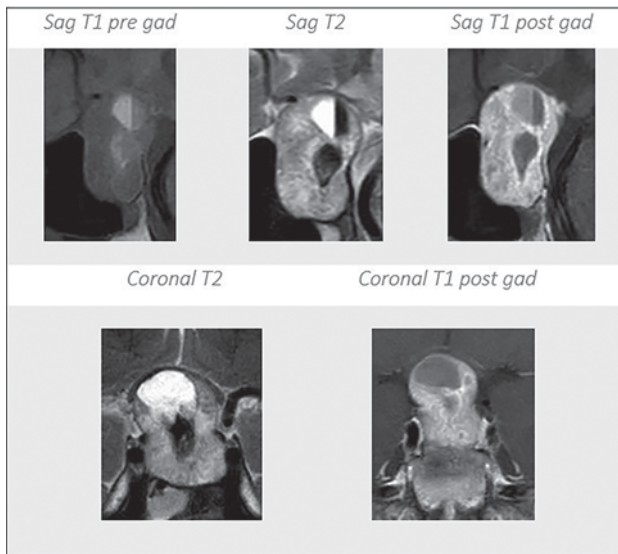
MR imaging of the sella shows internal hemorrhage with the hematocrit level on different sequences. Sag indicates sagittal; pre gad, pregadolinium; post gad, postgadolinium.
